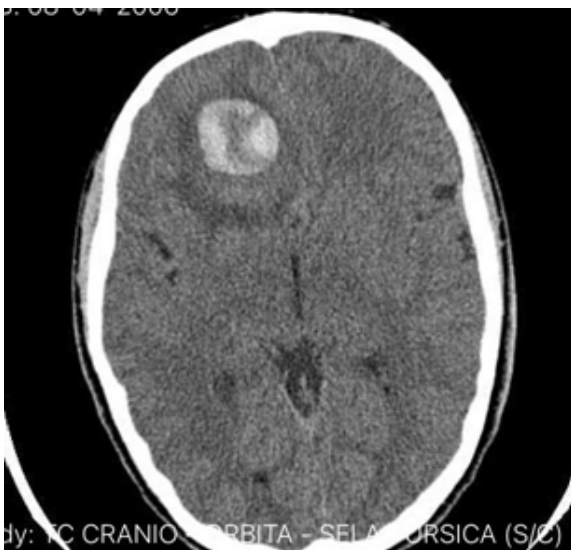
Entry CT scan showing right frontal cavernoma.
